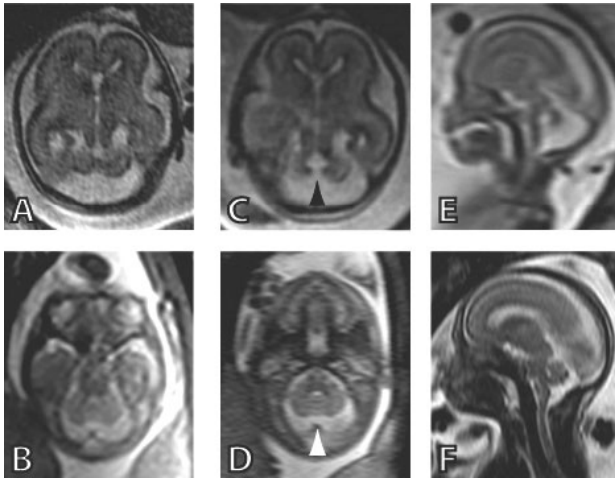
Fetal MRI of affected fetus (Case 1) at 21 EGA (A,C,E) and unaffected fetus (Case 2) 22 weeks EGA (B,D,F). (A–B) Superiorly, the midline cerebellum appears intact in both Case 1 (A) and Case 2 (B). (C–D) Inferiorly, a connection between the 4th ventricle and cisterna magna is apparent in the affected Case 1 (black arrowhead in C), but not in unaffected Case 2 (white arrowhead in D). (E–F) In midline sagittal views, Case 1 demonstrates a small vermis and above average size cisterna magna (E), versus the normal structures in Case 2 (F). Less cerebral cortex is visualized in (B,D) because the plane of section is more horizontal than in (A,C). EGA = estimated gestational age. See text for details of MRI acquisition
